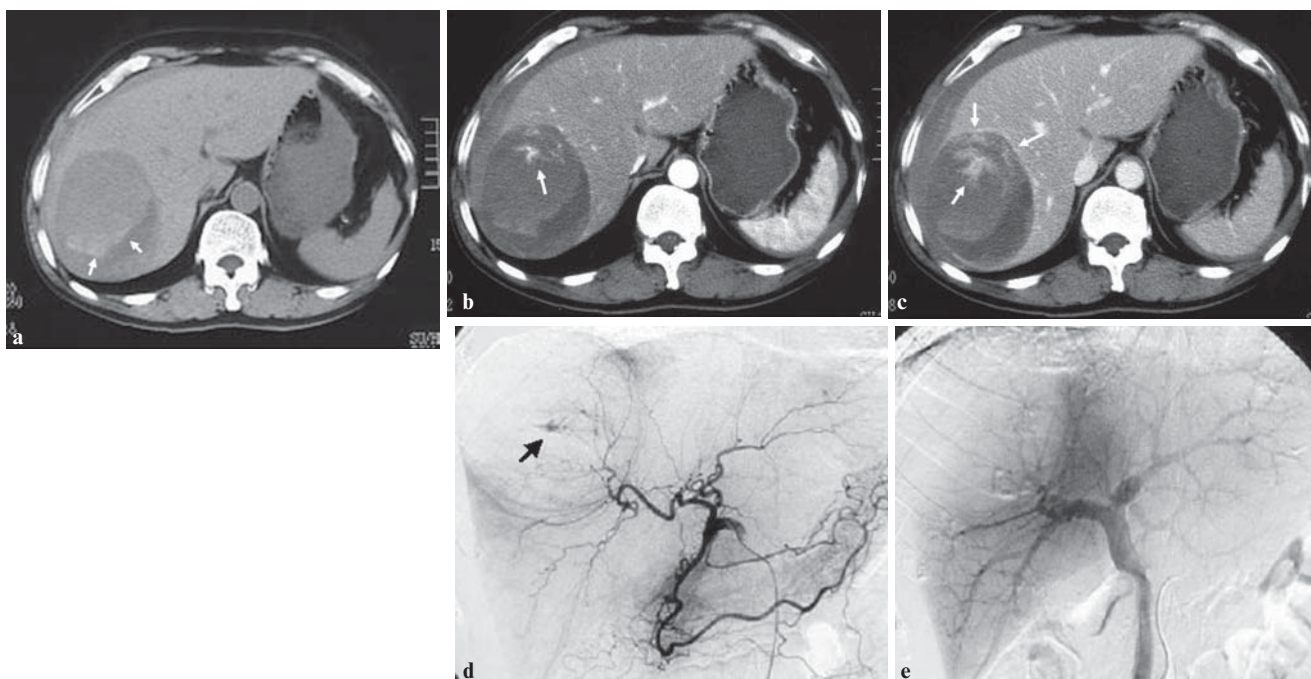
Solitary angiosarcoma with intratumoral hemorrhage and hemoperitoneum in a 57-year-old man. Note the hemoperitoneum anterior to the right hepatic lobe tumor. a Unenhanced computed tomography (CT) scan shows the right hepatic lobe mass, hypoattenuated to the liver and isoattenuated to the aorta. A high-attenuation intratumoral hemorrhagic liver mass (*arrows*) and hemoperitoneum were found. b Arterial phase contrast-enhanced CT scan shows the liver mass, hypoattenuated to the liver, with small patchy enhancement isoattenuated to the aorta (*arrow*) and with hypovascular areas reflecting necrosis. c Portal
